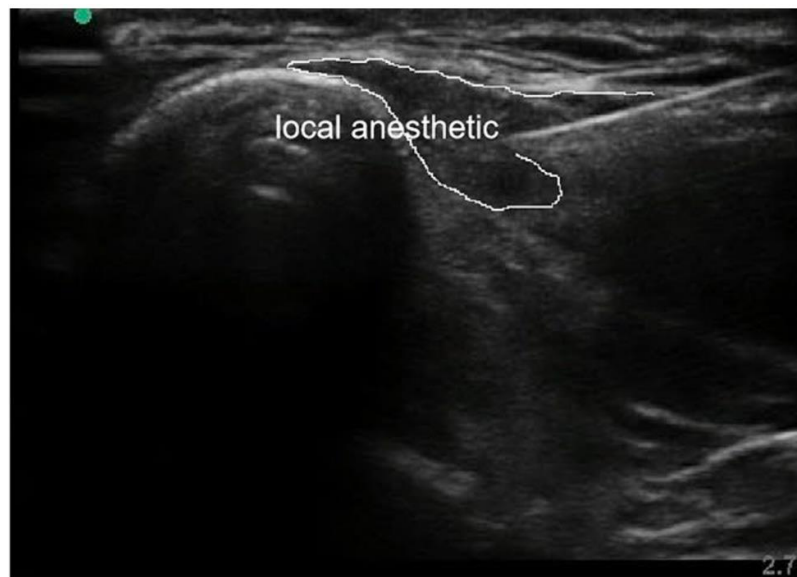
13 Sonographic image showing the local anaesthesia deposition
